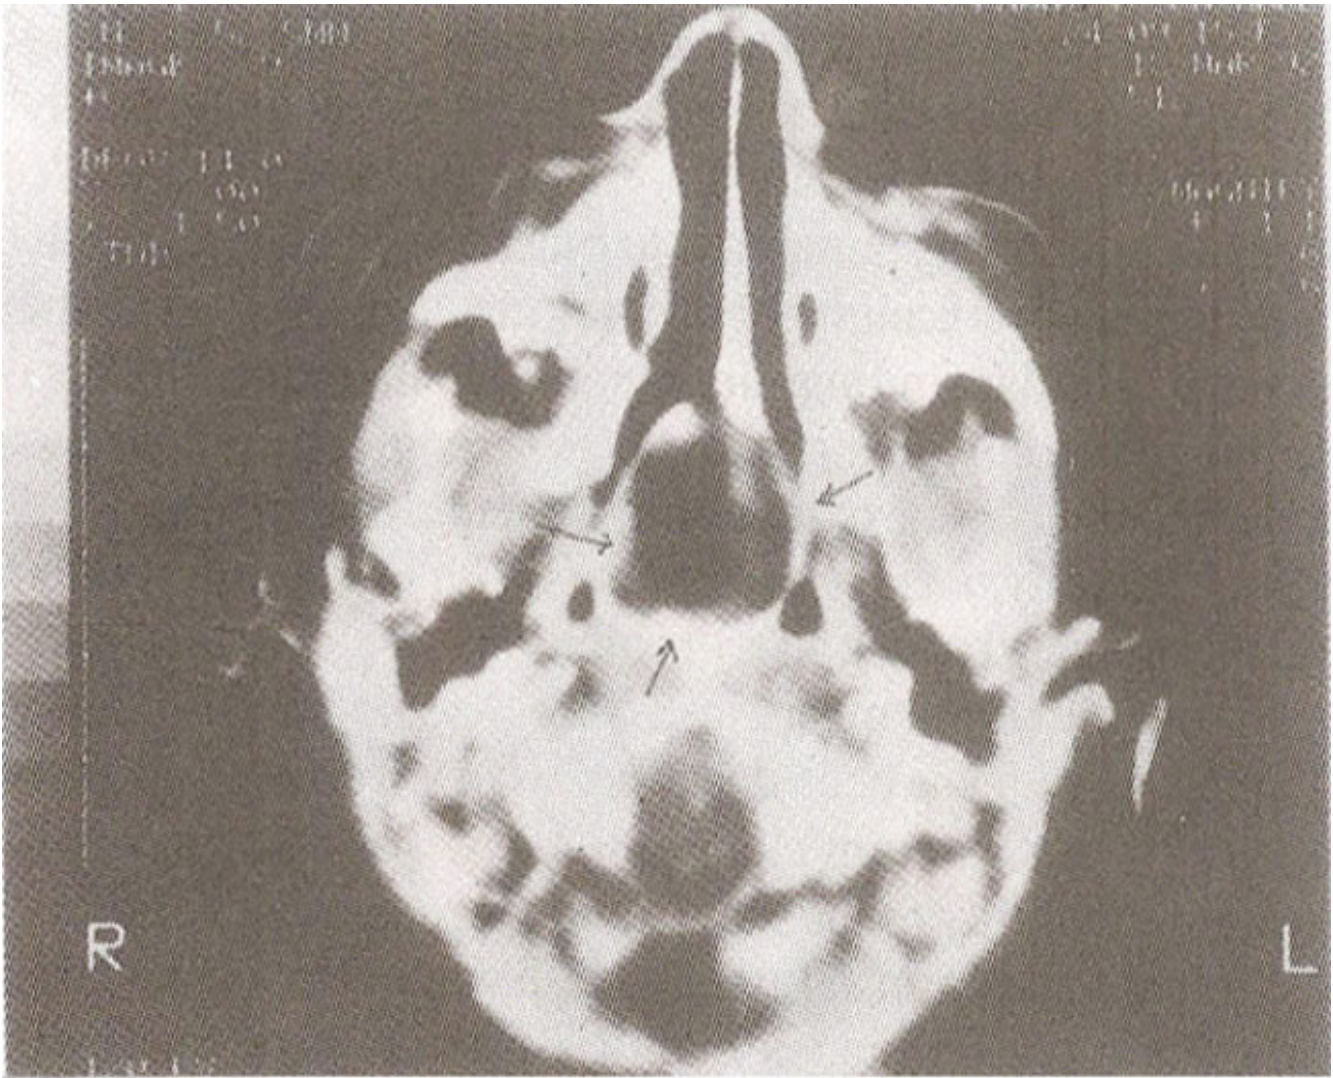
CT-Scan of the oropharynx. Arrows mark the tumour occupying the posterior nasal choanae. There is no intracranial communication.
